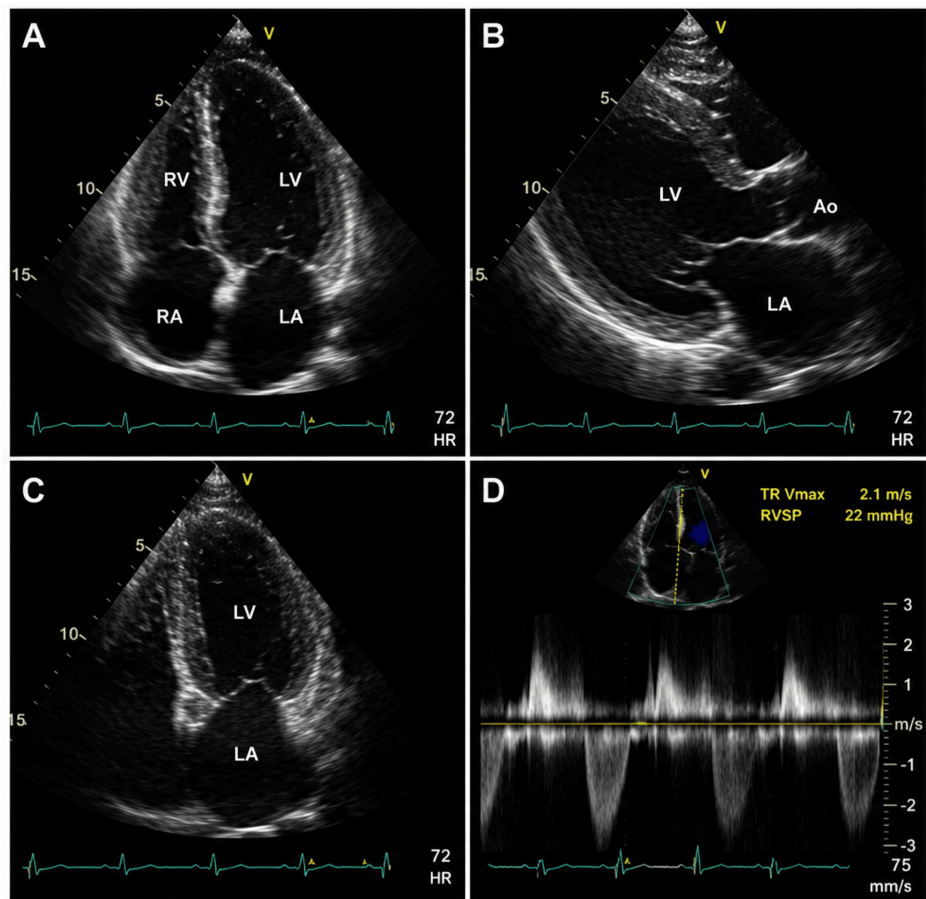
Transthoracic echocardiography.
